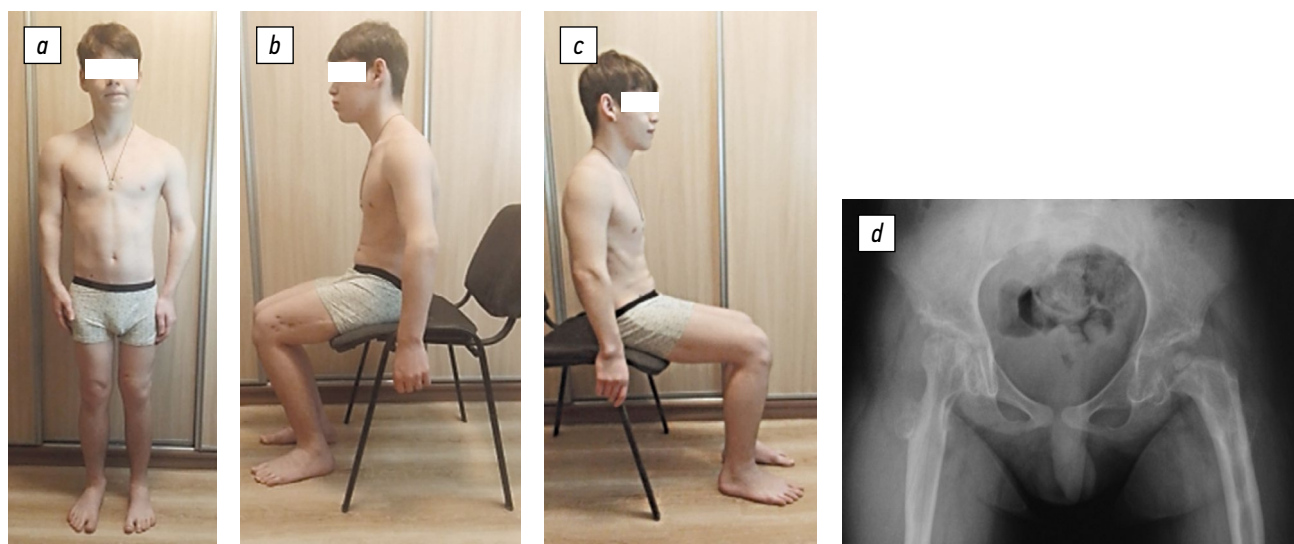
Appearance of the patient (a–c) and hip joint radiograph (d) after hip joint stabilization and left femur lengthening (2021)
